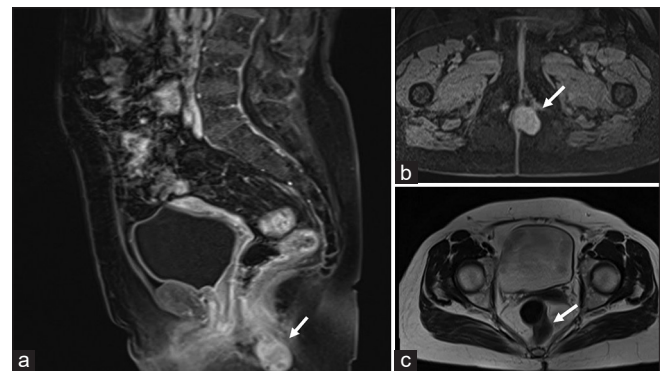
MR images (T1-weighted MR) of perianal angioleiomyoma, (a) Sagittal (T1-weighted fat suppressed axial section image with contrast enhancement) (marked by arrow), (b) Transverse section (T1-weighted fat suppressed axial section image without contrast enhancement) (marked by arrow) and (c) Transverse section (T2-weighted MR with heterogeneous and slightly hyperintense to muscle characteristics) (marked by arrow). MR: Magnetic resonance
